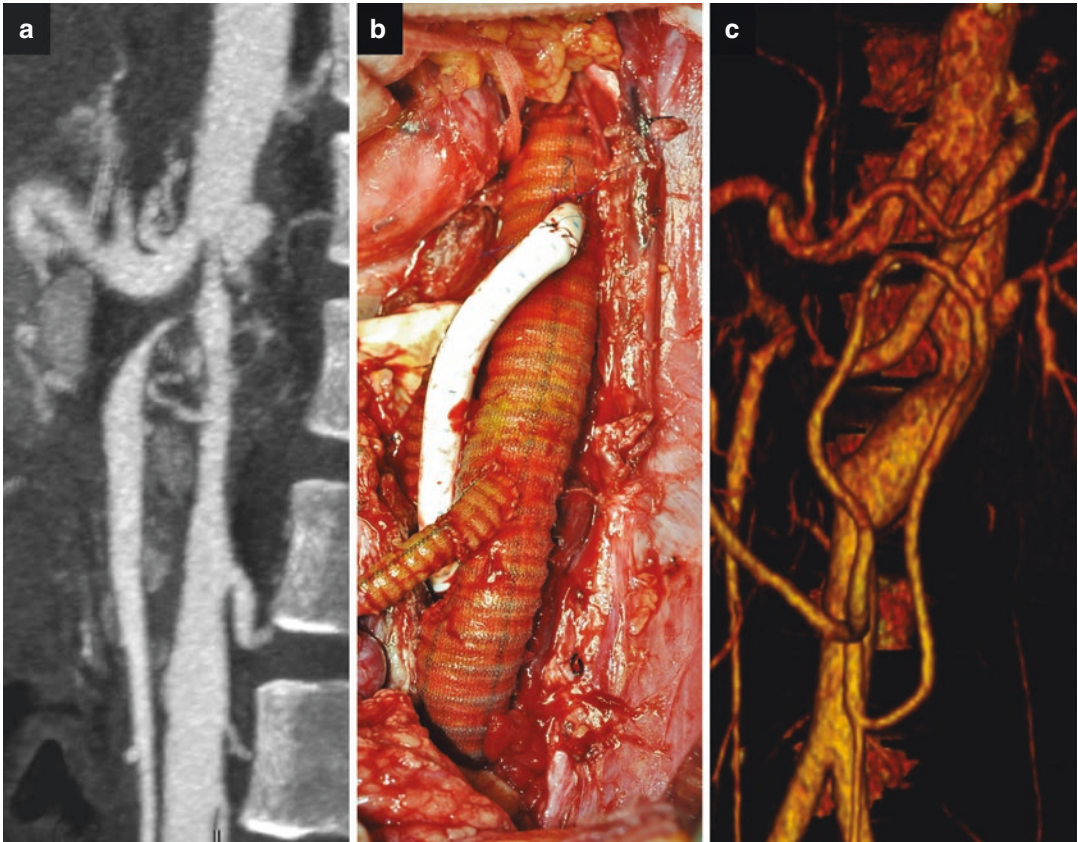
(a) Preoperative multiplanar CT reconstruction showing the pseudoaneurysm associated with a narrowed aortic lumen, severe stenosis at SMA origin, and left renal artery occlusion; (b) intraoperative finding after extensive
